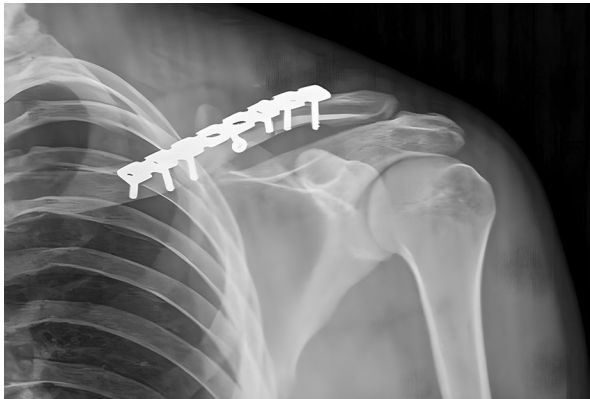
Post-operative X-rays with superior reconstruction plating.
